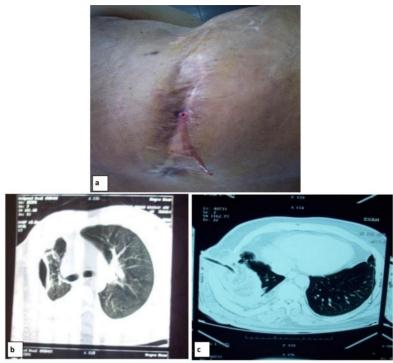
Patient with recurrent TB empyema cavity and bronchopleural fistula (3 previous operations): (a) Fistula on back with infected discharge and froth, (b) CT chest showing calcified wall of empyema cavity, (c) Intrathoracic muscle transposition.
